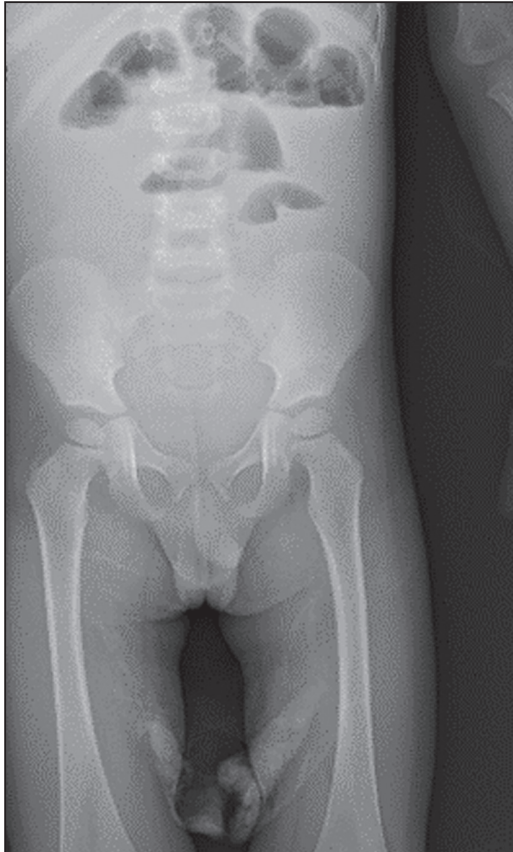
Plain abdominal X-ray showing multiple air fluid levels
